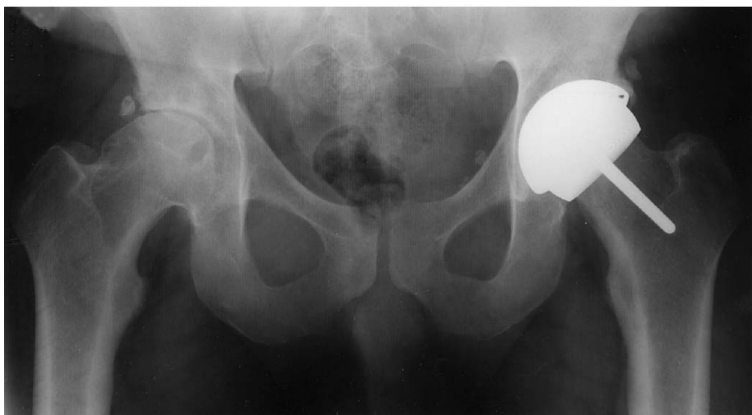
(A) A preoperative AP radiograph shows a 38-year-old man with end stage OA. Multiple femoral cysts on the radiographs and the inserted intraoperative picture (inset) of the femoral head taken after preparation can be seen. (B) An AP radiograph taken 2 years after hybrid metal-on-metal surface arthroplasty of the hip shows no evidence of component loosening.
